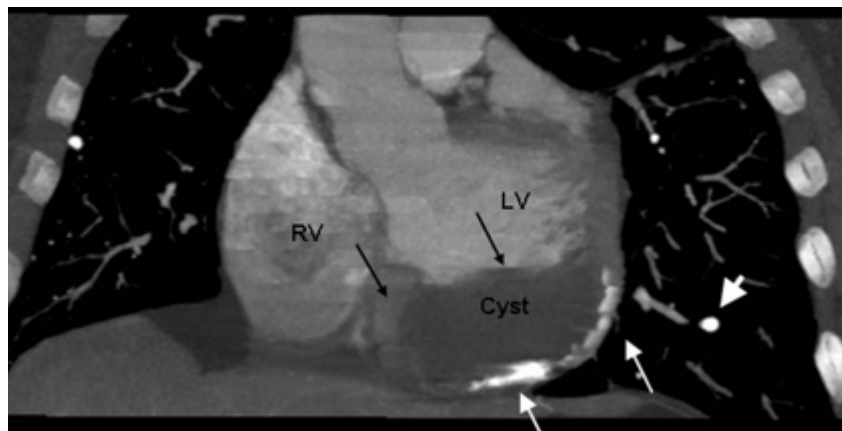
CT. an abnormal mass at the antero-basal (diaphragmic) side of the left ventricle (from archive radiology)
